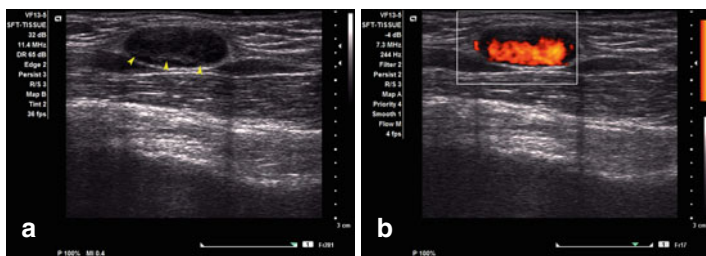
Benign lymph node with a prominent hilum (a arrow heads) highlighted by Doppler examination (b)
